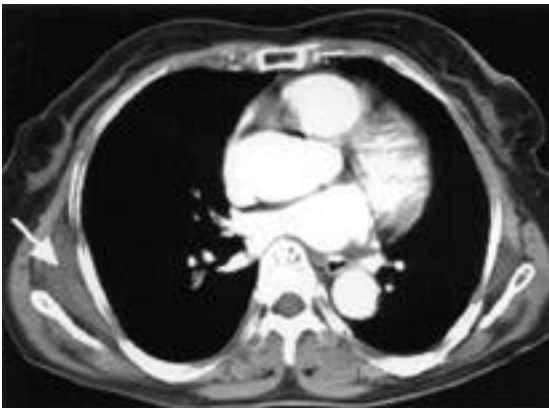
Axial noncontrast CT scan shows large subscapular mass(white arrow). Note subtle areas of decreased attenuation within mass.
